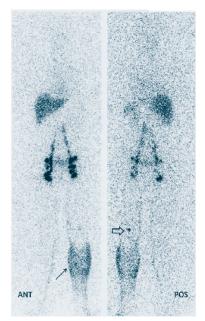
Four hour lymphoscintigram of a patient with left lower extremity lymphoedema. Note significant dermal backflow (arrow) in the calf, and visualization of a popliteal lymph node on the left side (hollow arrow).
